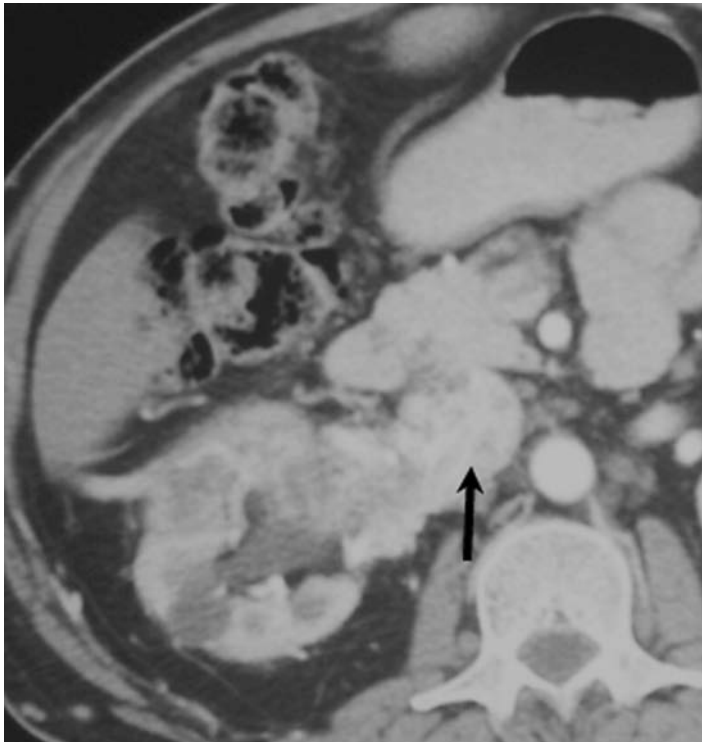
Contrast-enhanced CT in the nephrographic phase. There is a large advanced right-sided stage T4 TCC demonstrating invasion of the renal parenchyma, renal vein, IVC (arrow), and the duodenum.
